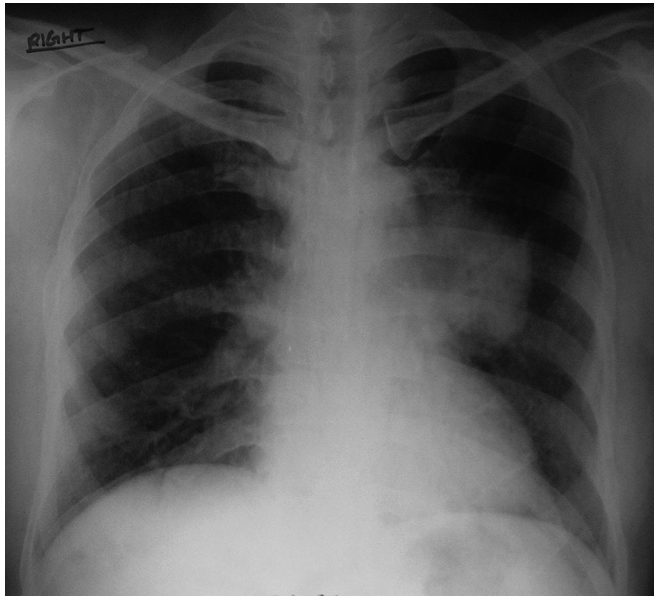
Chest X-ray of the patient before treatment.
